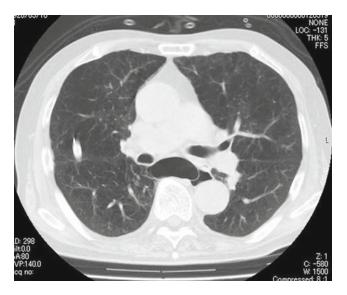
Chest computed tomography (CT) showing a bulla at the azygoesophageal recess
